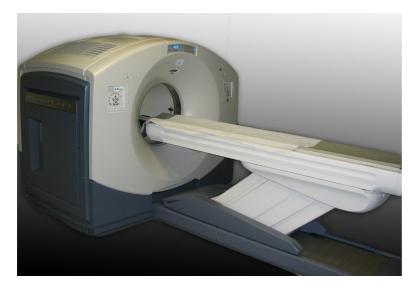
Photograph of a PET/CT machine developed by General Electric.
